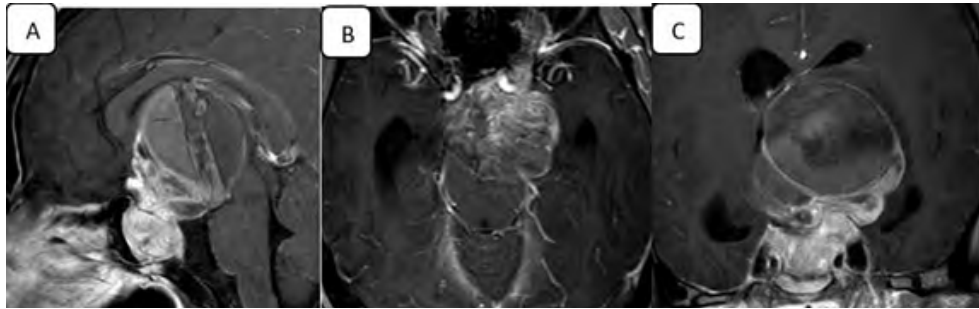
Enhanced MRI features of the sellar region in male patients with giant prolactinoma.
